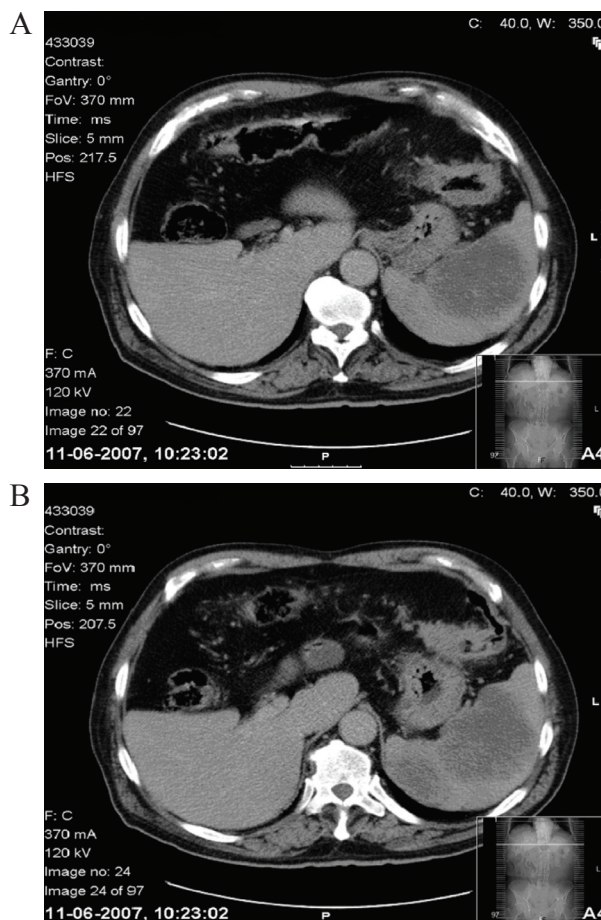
(A and B) Abdominopelvic computed tomography showing “[...]At the splenic flexure, an accentuated wall thickening is observed [...] (corresponding to colon neoplasm). Presence of adjacent fat densification and several grafts [...] It shows splenomegaly and multiples cold nodules measuring between 7.5 and 8.5 cm are evident, suggestive of metastasis [...]”.
